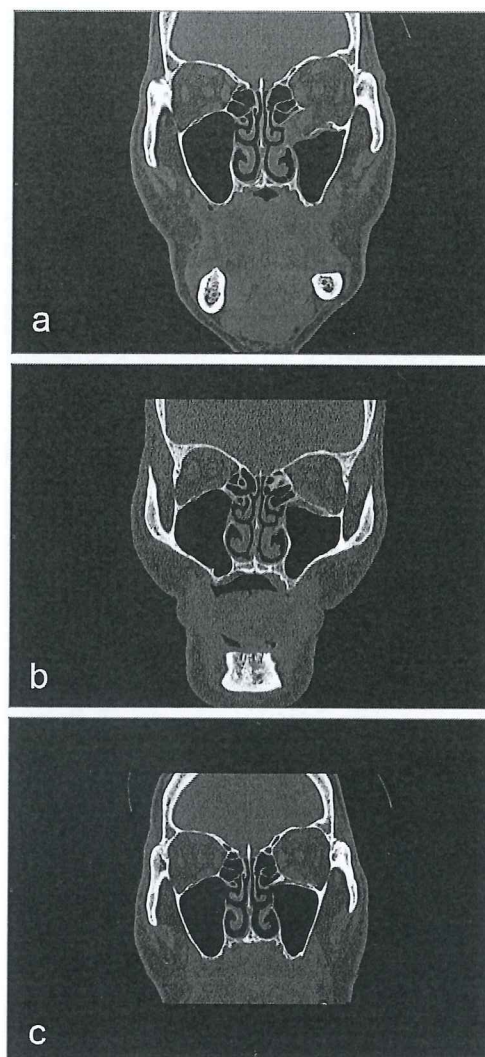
Coronal computed tomography findings in a 63-year-old man with orbital wall fracture caused by a fall. a, Preoperatively, the left orbital floor fracture and soft tissue herniation with a bony defect is seen. b, Two-months after the operation, the left orbital floor was reconstructed with the u-HA/PLLA sheet. c, Fifty-one months after the operation, satisfactory reduction and fixation was maintained.
